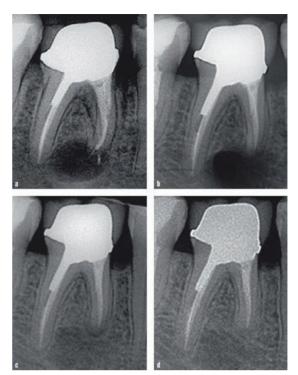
Example of periapical healing after endodontic surgery with Biodentine® placement during retrograde filling of the mesial root of 46. (a) Preoperative vie. (b) Immediate postoperative view. (c) One year after surgery. (d) Two years after surgery (Boucher et al. 2021)
